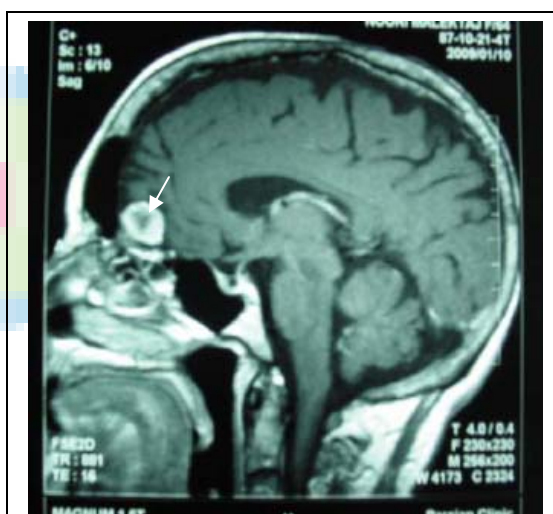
Brain MRI shows meningioma (arrow).
